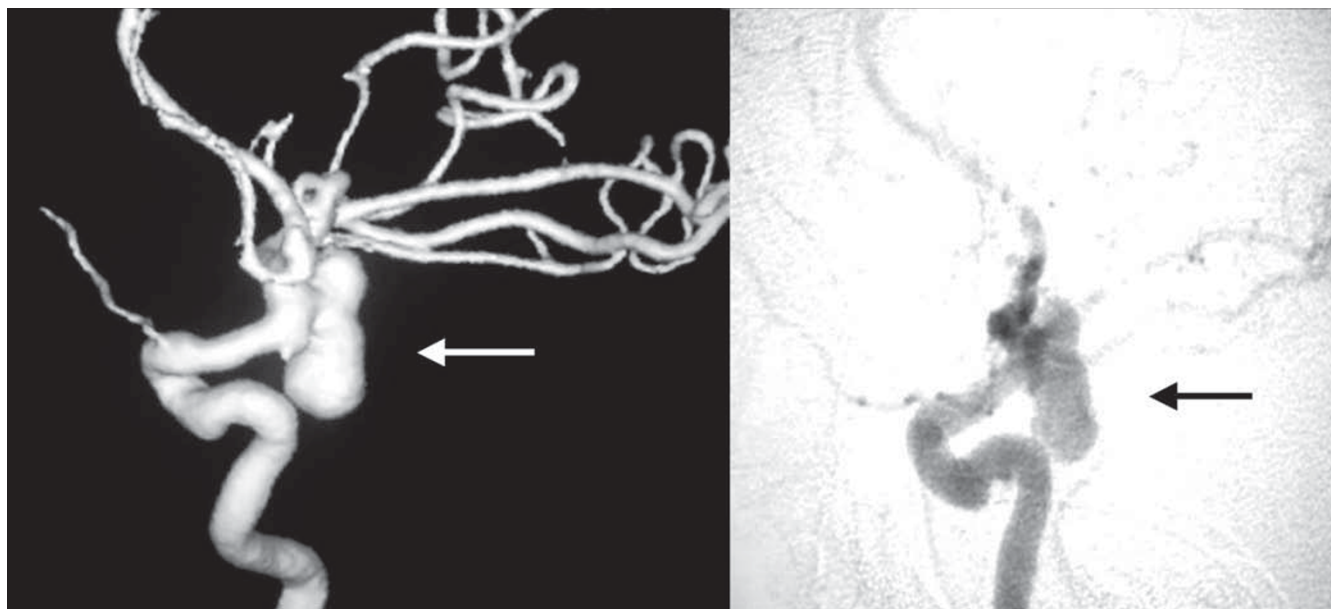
Cerebral angiography (right panel) and angio-MRI (left panel) showing a large intracranial aneurysm (arrows) located at the left internal carotid artery
